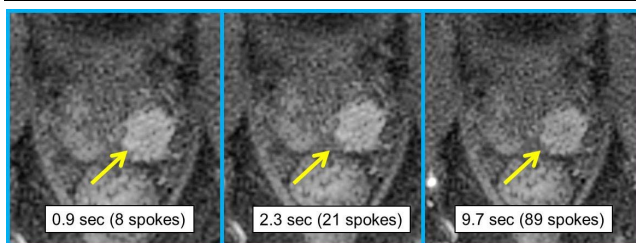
Similar appearance of left PZ Gleason 4+4 tumor from various retrospective reconstructions of single GRASP DCE-MRI data set at different temporal resolutions.
